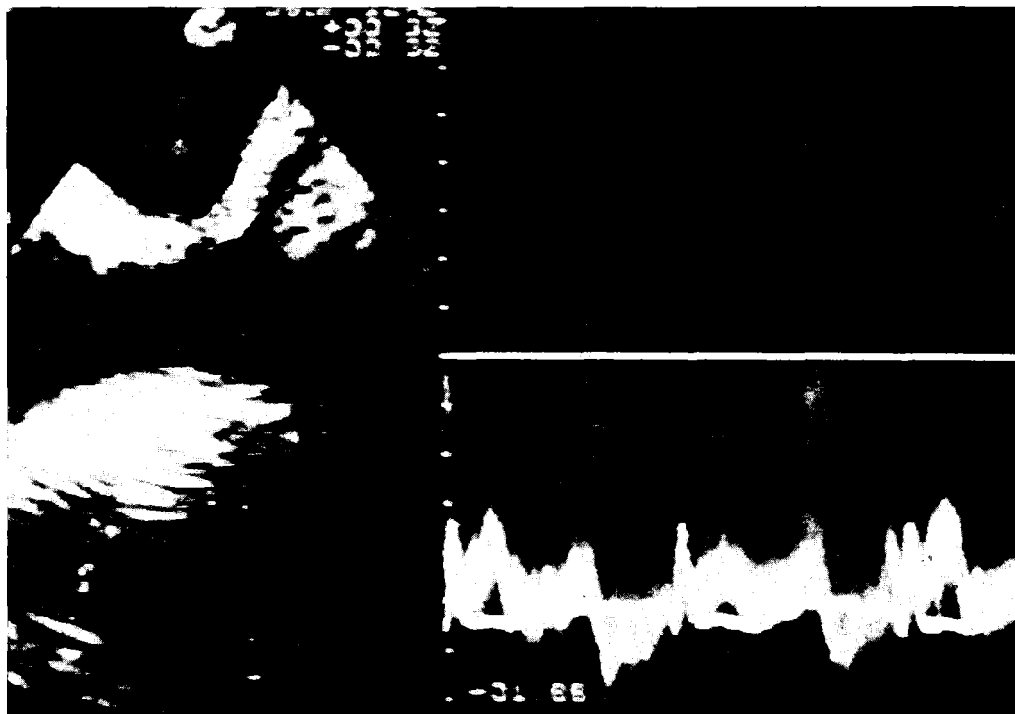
Moderate pulmonary venous obstruction as seen from the esophageal approach. The Doppler sample volume is placed at the site of the obstruction and reveals a continuous velocity profile (1.8 m/s), which does not reach baseline throughout the cardiac cycle.
